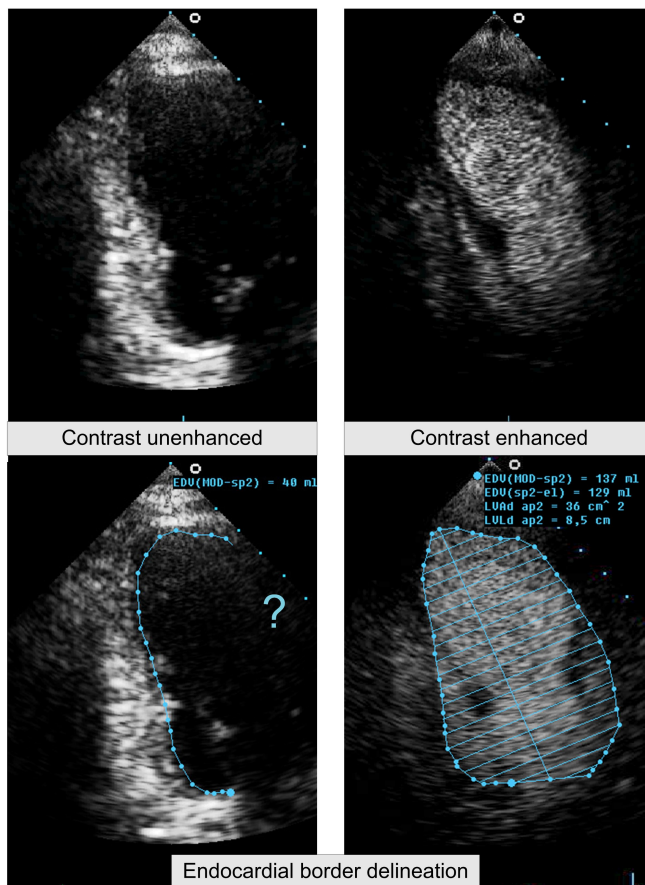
Heart left ventricle recorded from apical position. Bottom images show that contrast enhancement using an ultrasound contrast agent improves the detection of the heart wall border, which is useful to study the wall motion and the ejection fraction of the heart. Images by courtesy of Dr. F.J. ten Cate of the Erasmus MC, Rotterdam, the Netherlands.
